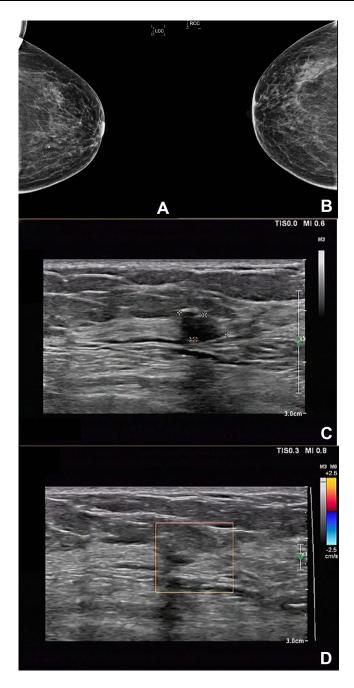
Figure I Results of a patient tested positive for breast carcinoma. (A and B). Molybdenum target X-ray results. (C and D). High-frequency color Doppler flow imaging (CDFI) results.
